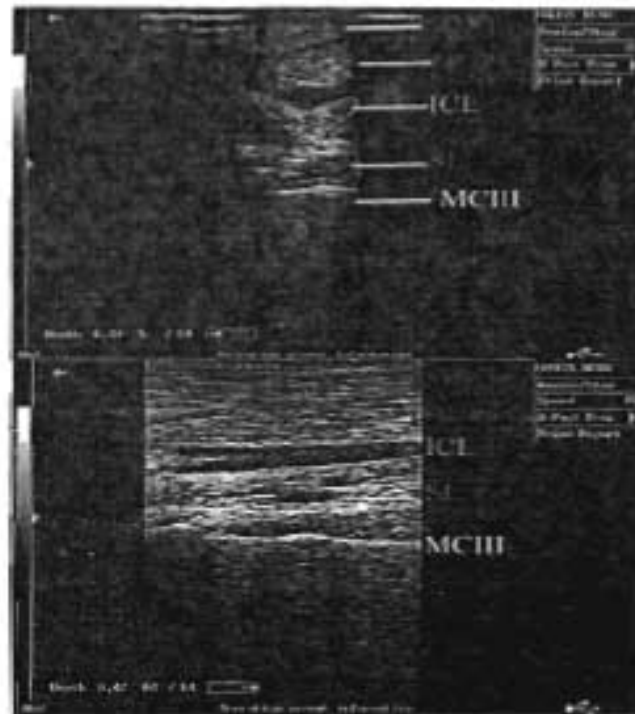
Transverse (A) and longitudinal (B) sonogram of the normal flexor tendons at the proximal metacarpal/metatarsal region showing the normal echogenicity and fiber alignment of the SDFT, DDFT, ICL and SL.
